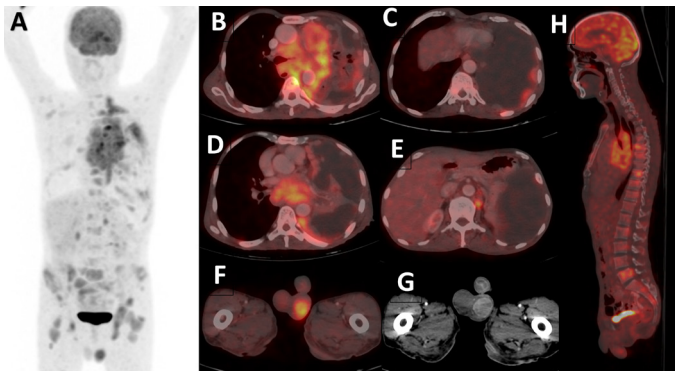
Whole-body 18F-FDG PET-CT images demonstrating disseminated metastatic disease (A) Maximum intensity projection (MIP) image showing increased FDG uptake in the left hemithorax, along with multiple foci of increased FDG uptake in the left supraclavicular, mediastinum, upper abdomen, visualized skeleton and left testicular region. (B-D) Axial fused PET-CT images showing intense FDG uptake in the left lung upper lobe primary tumor and mediastinal nodal metastases. (E) Axial fused PET-CT image showing FDG-avid abdominal lymphadenopathy. (F-G) Axial fused PET-CT and corresponding CT images showing an intensely FDG-avid heterogeneously enhancing lesion in the left testis. (H) Sagittal fused PET-CT image showing extensive FDG-avid skeletal metastases involving the axial skeleton.
